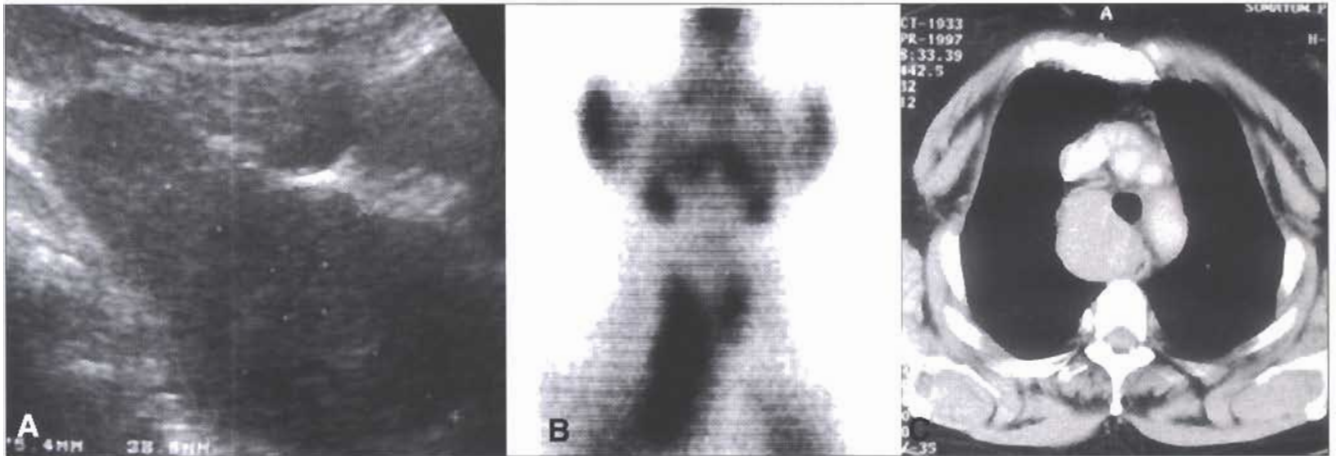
Patient 1: sarcoidotic lymph node. A) Ultrasound: at the infrajugular right parasagittal site is present a scarcely echoic, huge mass with sharp edges. B) ⁹⁹Tc-MIBI Scintigraphy: image obtained 90 min after injection of the tracer; a "hot" spot is shown in the upper mediastinum-low neck. C) Computed tomography: on the right side of esophagus and trachea, a scarcely contrast- enhanced mass is present.
